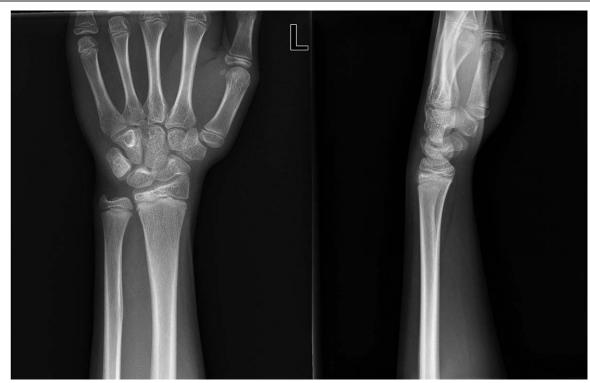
Anteroposterior and lateral radiographs showing the healed physeal fracture.
